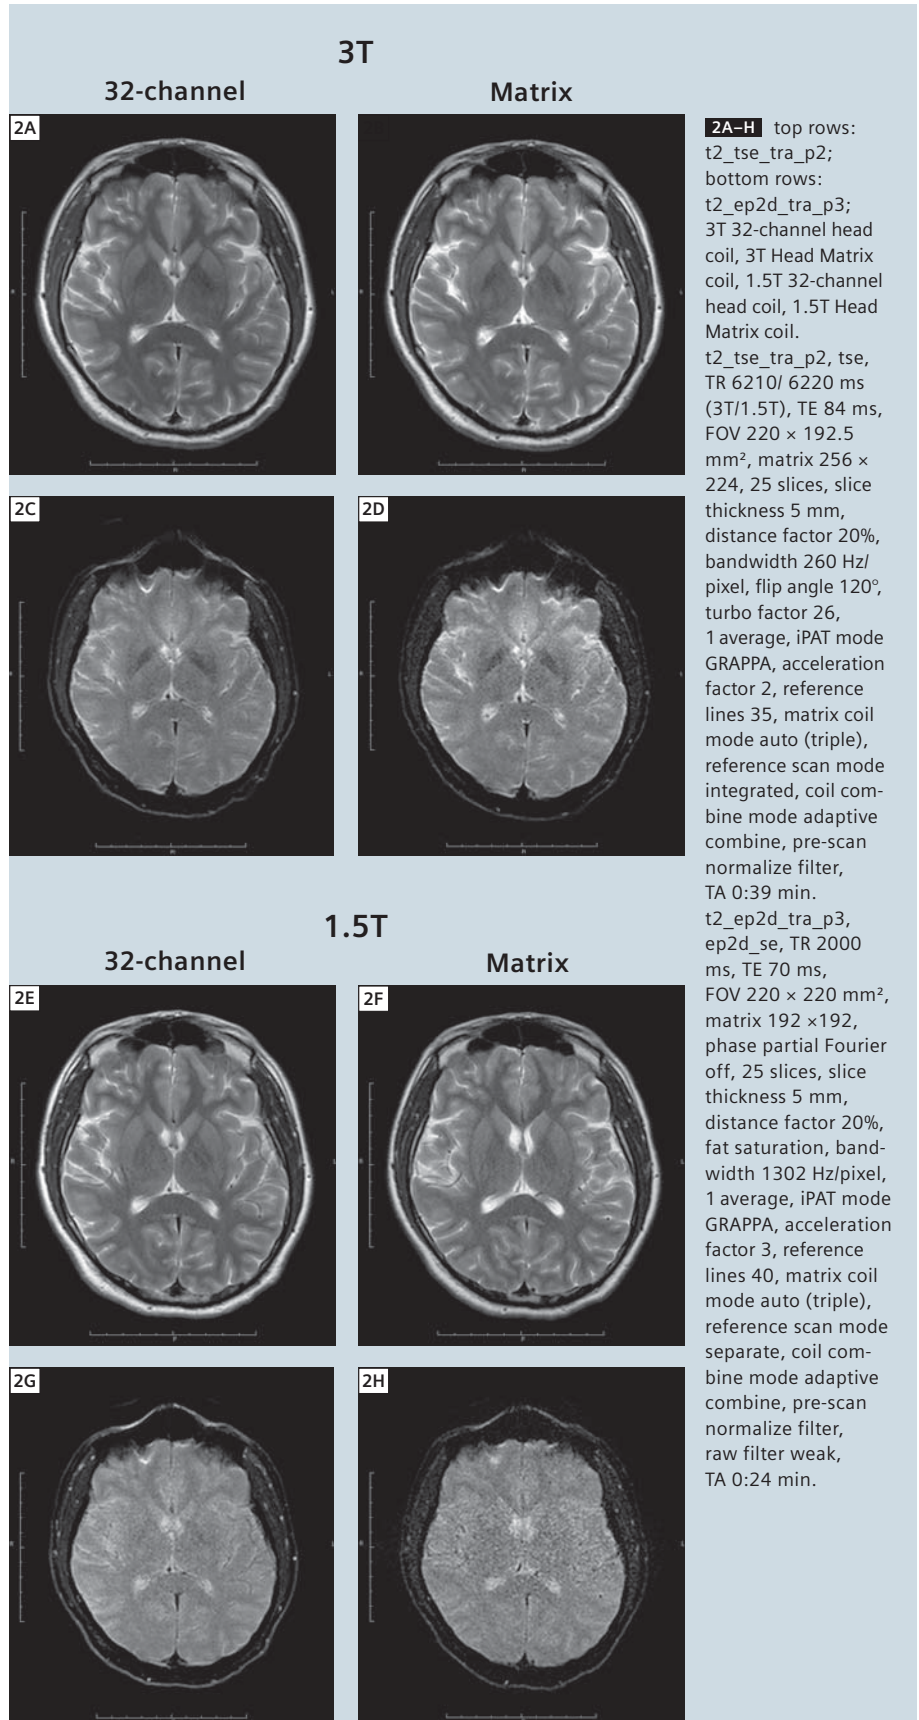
shows T2-weighted images acquired with a conventional TSE scan and an EPI scan. At similar scan times (t2\_tse\_tra\_p2, 0:39 min vs. t2\_ep2d\_tra\_p3, 0:24 min) the image quality of the TSE data is superior in terms of SNR, contrast, distortions and susceptibility artifacts. The same effect is shown in Figure 3 where images from conventional FLAIR scans are compared to EPI based FLAIR scans (t2\_tirm\_tra\_dark-fluid\_p3, 1:40 min vs. t2\_ep2d\_tra\_p3, 1:47 min). At comparable scan time, the image quality of the conventional scans is superior. The same was found for the T1-weighted scans (images not shown).
